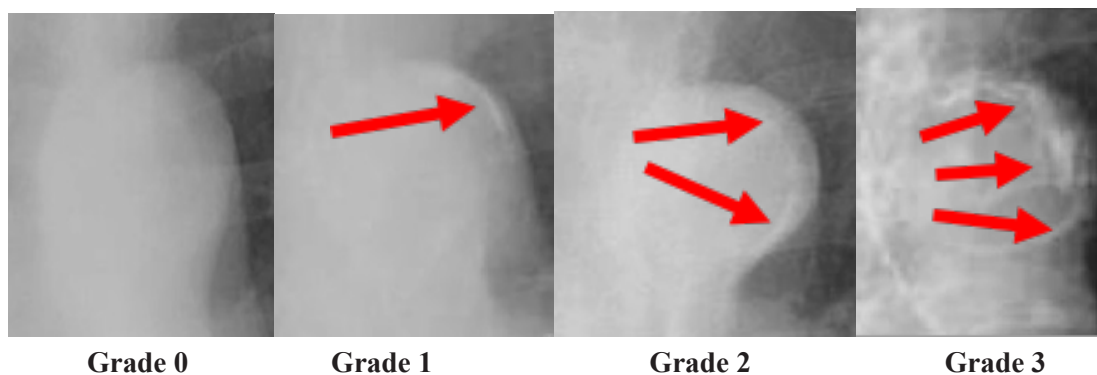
Grading of aortic arch calcification on plain Chest X-Ray.
